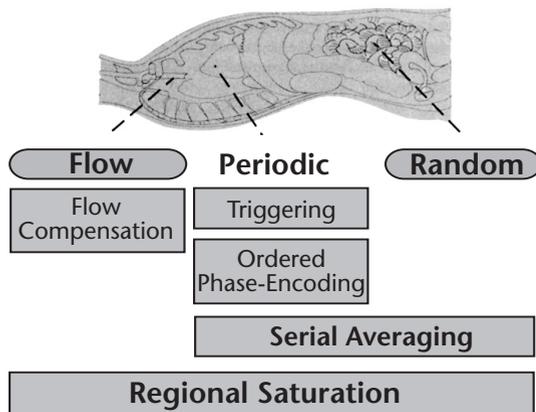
Various types of motion that produce artifacts in MR images and correction techniques.
